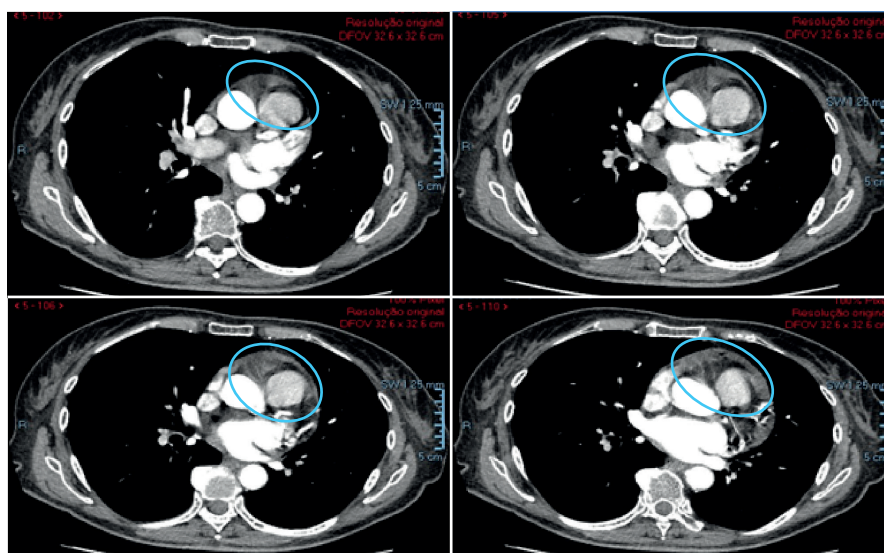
MDCT angiography: the bulky and poorly delimited infiltrative lesion (blue circles) affecting the RV, notably its tip and its lateral and anterior walls, as well as the distal interventricular septum, extending through the whole myocardium thickness with protrusion into the pericardial space, associated to moderate pericardial effusion. MDCT, multidetector computed tomographic; RV, right ventricle.
